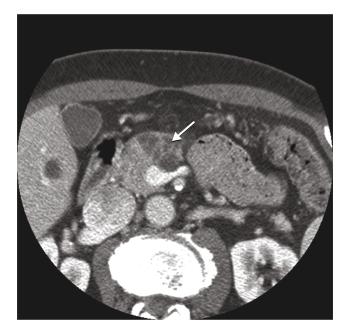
Serous Cystadenoma. Computed tomogram shows a serous cyst. The mass lesion in the head of the pancreas consists of multiple small cystic lesions (arrow). The findings are typical of serous cystadenoma.
